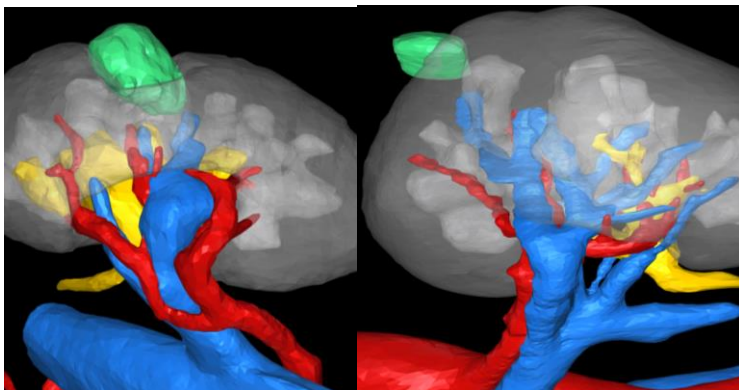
Smaller and lower complexity tumours. (Left) The 3D model was still useful for reconfirming intraoperative ultrasound findings that showed a dip in tumour, towards the right in the image, which helped to plan the excision. (Right) Small proximal and exophytic tumour and with single feeding artery. For this simpler case the 3D model was not needed but it did reconfirm the intraoperative findings.
